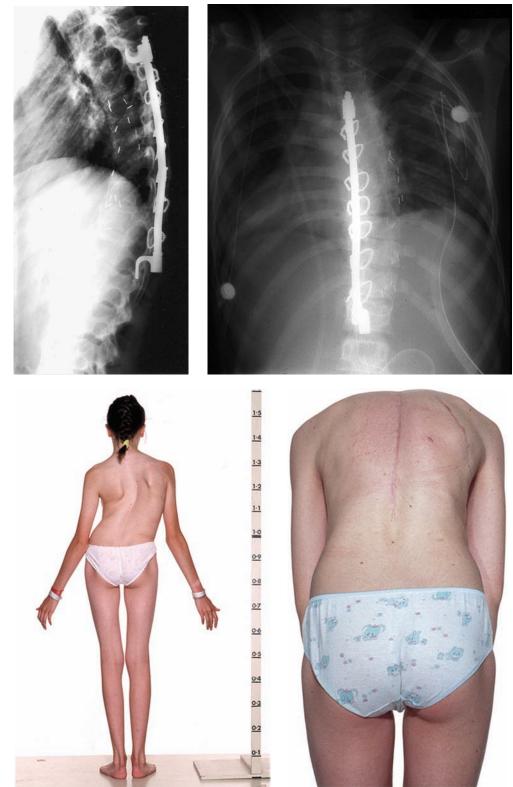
The "Leeds Procedure." (A) PA X-ray film of a rigid 90degree idiopathic thoracic curve. (B) PA X-ray film in recovery after anterior multiple discectomy (five discs removed). There has already
